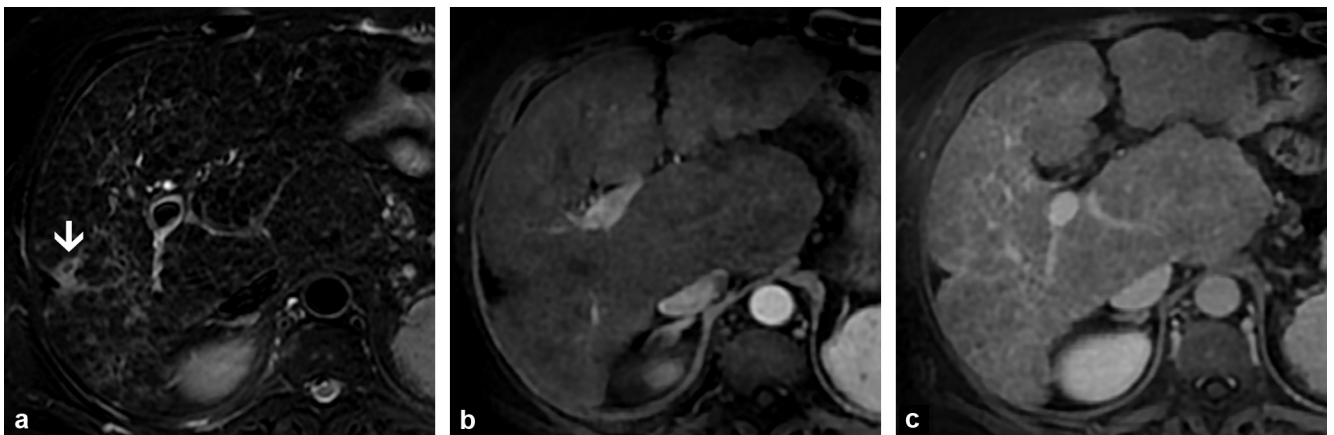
Peripheral confluent fibrosis. Monitoring examination for cirrhosis of exogenous and metabolic origin. T2-weighted (a) and T1-weighted MRI with fat saturation in the arterial (b) and late (c) phases: peripheral confluent fibrosis with capsule retraction (arrow) with T2-weighted hyperintensity, with no enhancement in the arterial phase but gradually enhancing in the late phase (after 3 min).
